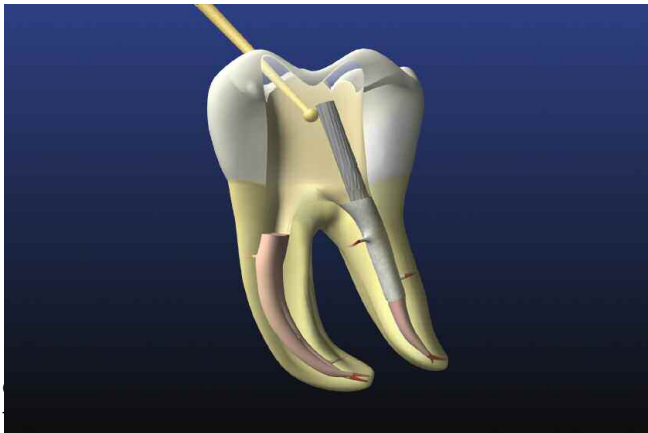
The ProUltra Endo Tip #1 has a working-end ball that, when ultrasonically energized, can be used to powerfully vibrate against all aspects of the exposed post.
